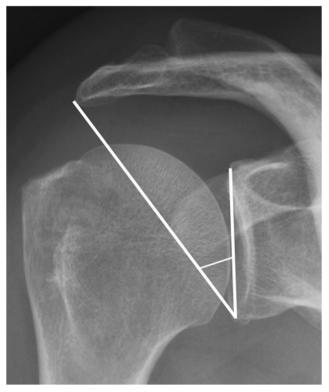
Anteroposterior radiograph of the shoulder. The critical shoulder angle (CSA) is the angle between the glenoid axis and the line through the inferior edge of the glenoid and the lateral extremity of the acromion
